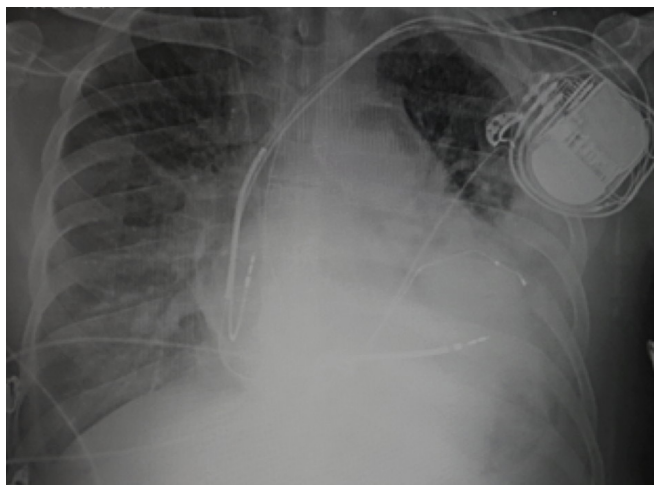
Chest radiography after ECLS implantation.
